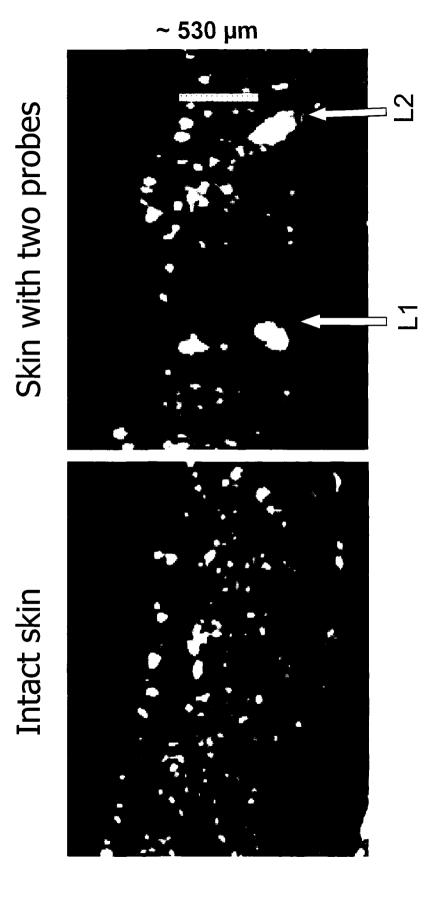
B-mode ultrasound scanning (Derma scan) depicting two linear probes in the skin (L1: Incision probe; L2: Intradermal probe).
